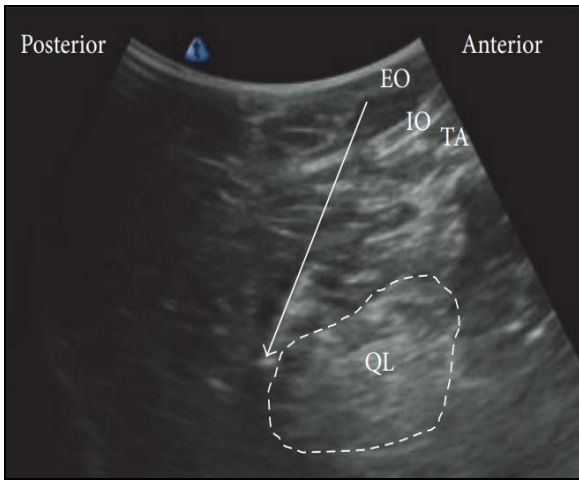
Images of the posterior QLB using ultrasonography. Two types of injections are (A) pre-and (B) post-injections. EO is for the external oblique muscle, IO stands for the internal oblique muscle, TA stands for the transversus abdominis, QL stands for the quadratus lumborum, the white arrow represents the needle trajectory, and the white dotted line represents the distribution of the local anaesthetic [21]
